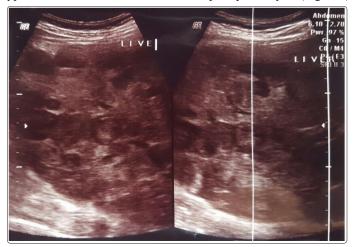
Sonographic study shows multiple hypoechoic lesions of variable sizes disseminated throughout hepatic parenchyma
